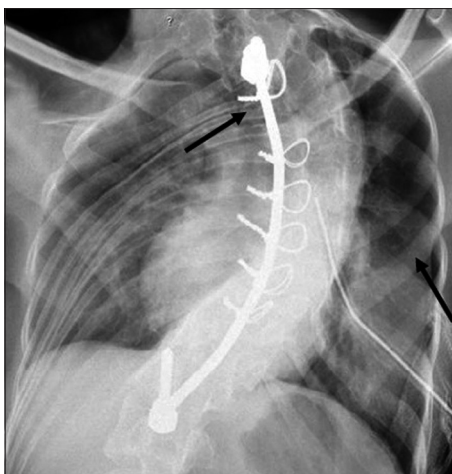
Chest radiography displaying a large pneumothorax with complete atelectasis of the left lung and airway distortion with deviated trachea and bilaterally narrowed bronchi
